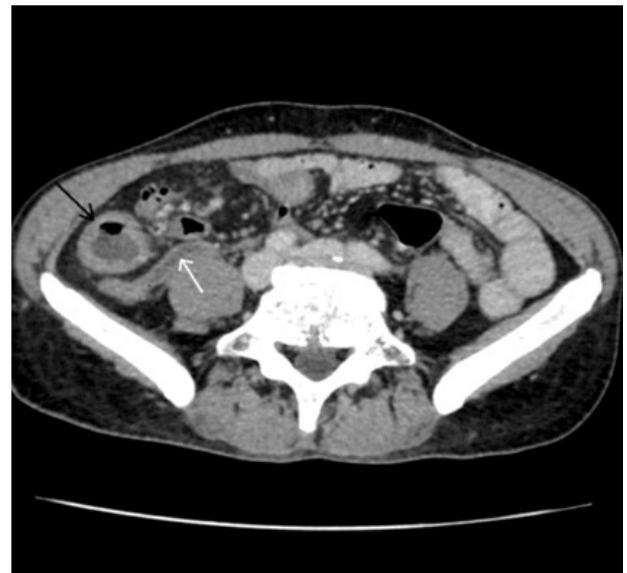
Acute appendicitis . Axial contrast enhanced CT shows symmetrical wall thickening in the caecum (black arrow) with fluid filled dilated appendix resting over the right psoas muscle (white arrow)
